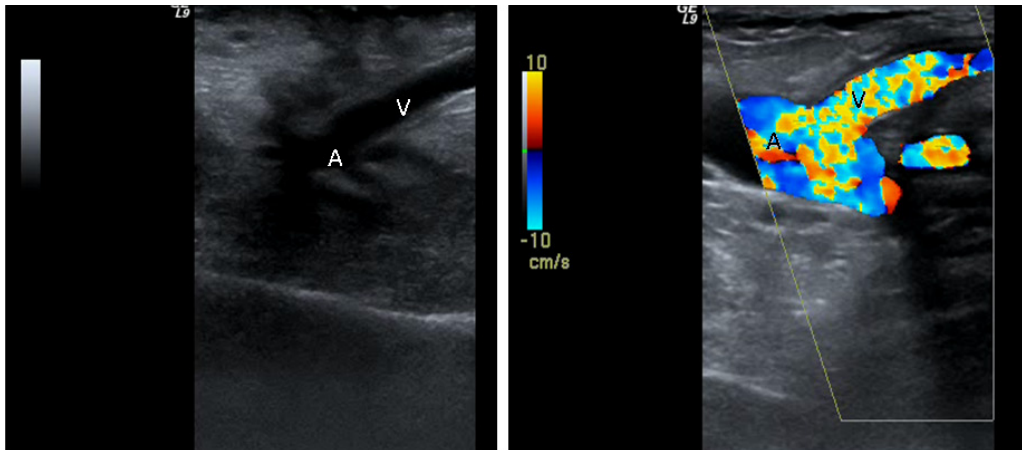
Normal end to side anastomosis of the vein (V) to the artery (A) on B-mode (left) and colour Doppler (right) ultrasound.
